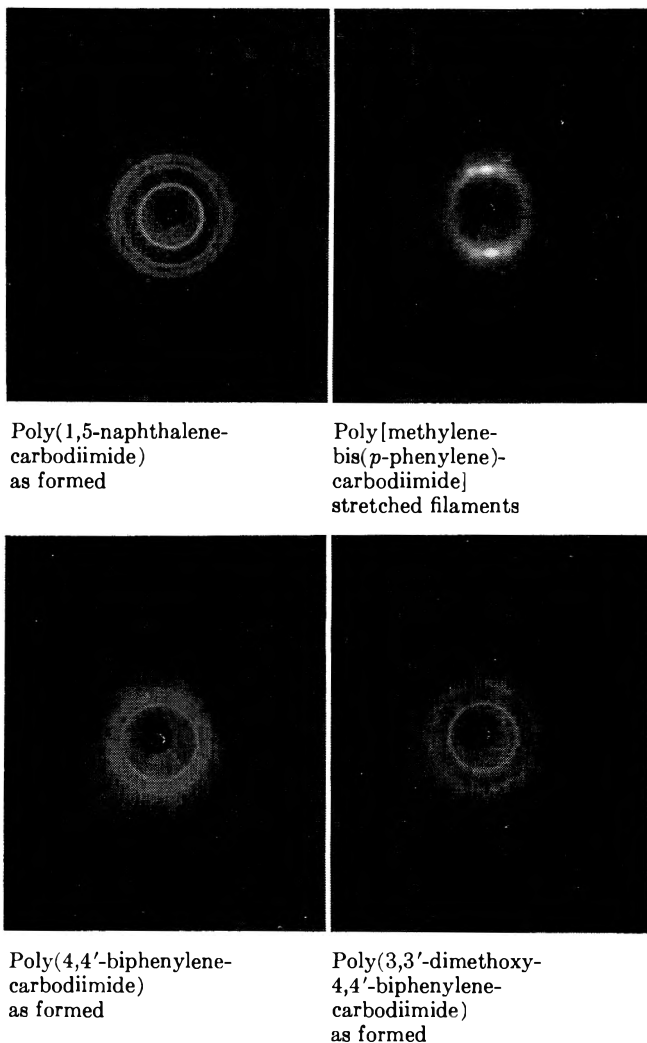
X-ray patterns of polycarbodiimides.
